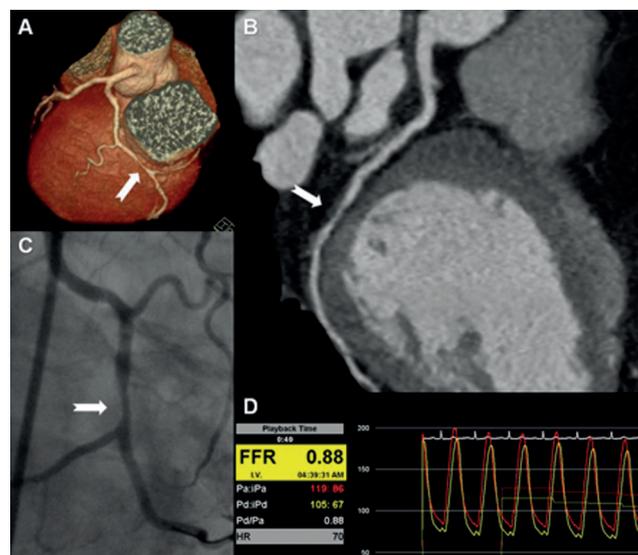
Comprehensive assessment of an intermediate coronary lesion with computed tomography coronary angiography (CTCA), invasive coronary angiography (ICA) and fractional flow reserve (FFR). A 51-year-old male patient presenting with coronary artery stenosis (arrows) in the left circumflex artery. A: volume-rendered image; B: curved multiplanar reconstruction; C: invasive coronary angiography. By visual assessment, the coronary lesion was estimated as moderate by ICA and as severe by CTCA. By quantitative analysis, the percent diameter stenosis was 50% by quantitative coronary angiography and 55% by quantitative CTCA. The FFR was 0.88; D: Based on the physiological assessment of this anatomically intermediate stenosis, percutaneous coronary intervention was deferred.
